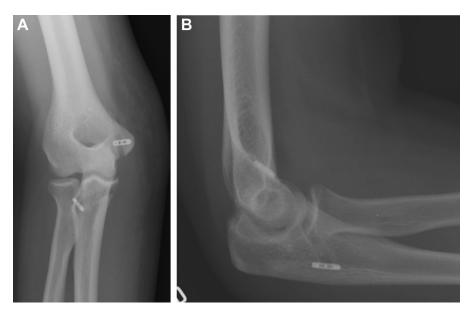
(A) Anteroposterior and (B) lateral postoperative radiographs demonstrating button and tunnel placement.
